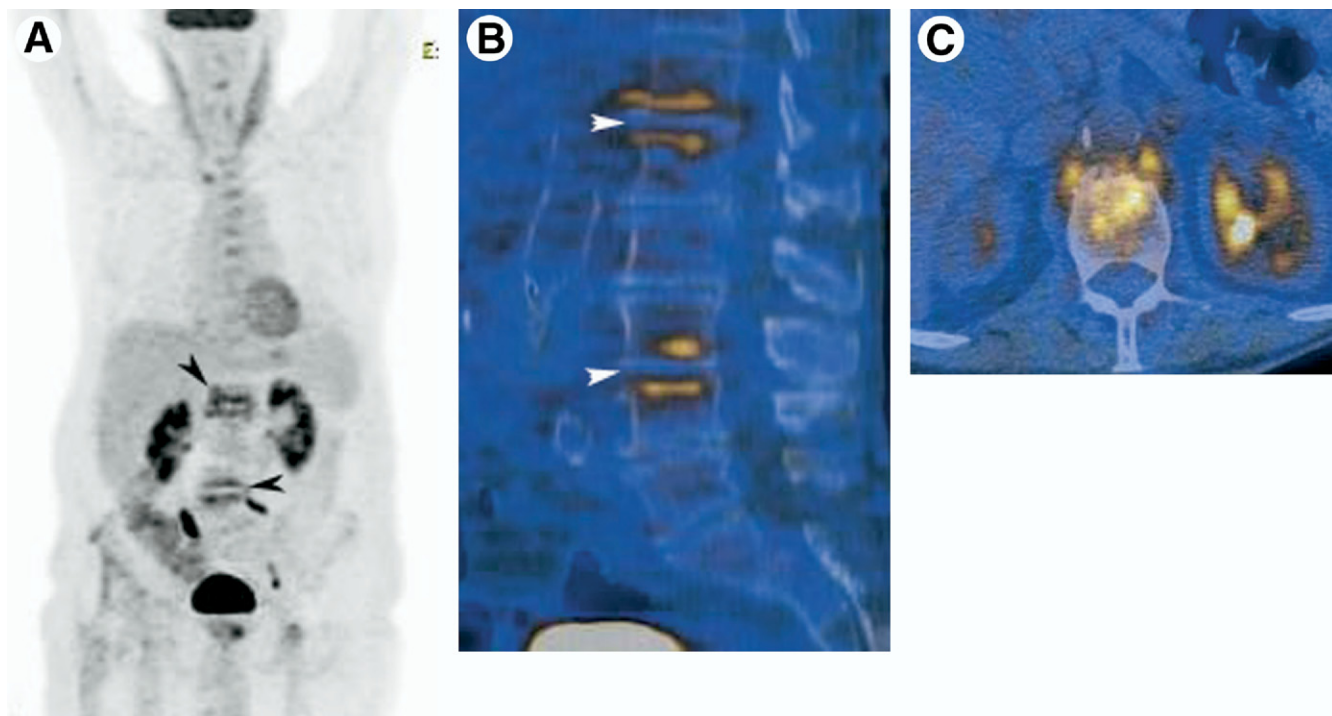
A 72-year-old man with fever of unknown origin. (A) MIP shows linear increased FDG uptake in the upper and lower lumbar spine (black arrowheads). (B) Sagittal PET/CT image shows FDG uptake in the endplates of the vertebral bodies L1-L2 and L4-L5 (white arrowheads). (C) On axial PET/CT scan, additional increased FDG accumulation in the soft tissues ventrally to L1-L2 is seen. Disc space infection at L1-L2 and L4-L5 intervertebral disc level was confirmed.
